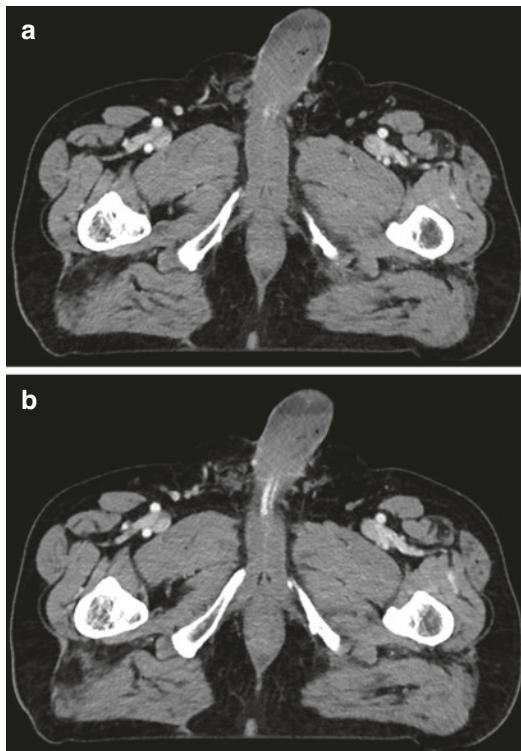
A 71-year-old man was admitted to the emergency department following a motor vehicle collision. Two contiguous IV contrast-enhanced CT images show the penis swelling midway down the shaft of the corpus spongiosum and gas bubbles (a, b), which was initially interpreted as a penis injury. Review of the history revealed that the patient had a prostaglandin injection into the cavernous bodies just before getting into the car. Comment: in trauma patients, a careful medical history, when possible, is strongly advised to avoid image misinterpretation
